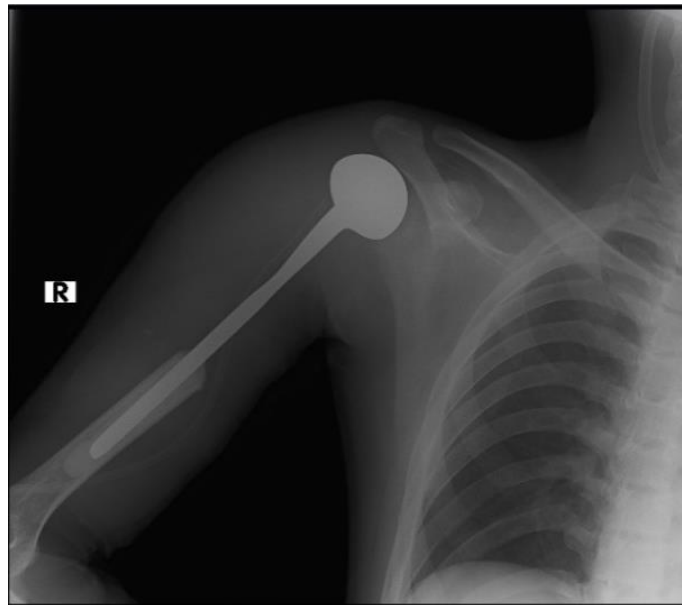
Post-operative right shoulder radiograph
